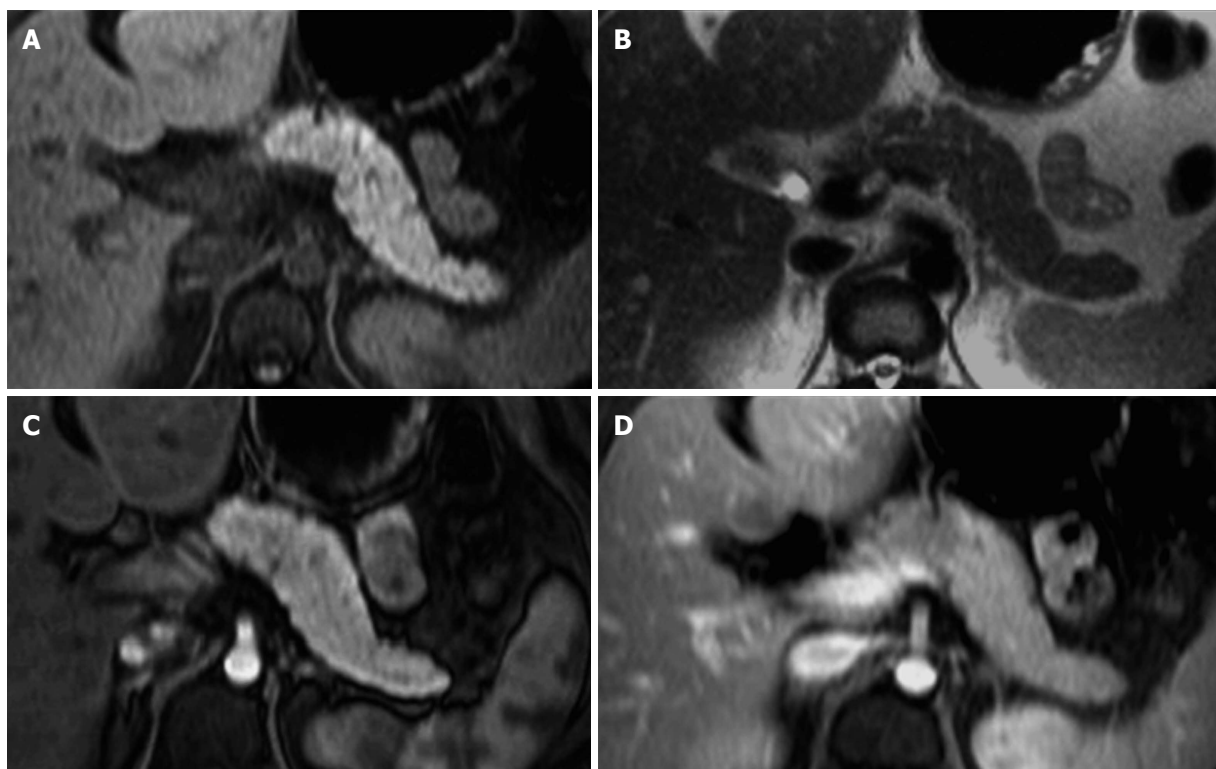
Normal pancreas. Axial T2-weighted SS-ETSE (A), pre-contrast fat-suppressed T1-weighted (B) GRE and post-gadolinium fat-suppressed T1-weighted gradient echo images acquired in the arterial (C) and venous (D) phases of enhancement. The normal pancreas is high in signal intensity on T1-weighted images (B) due to the presence of aqueous protein in the pancreatic acini. A uniform capillary blush is apparent on the immediate post-gadolinium image (C). T2-weighted sequences allow the depiction of the pancreatic duct. SS-ETSE: Single-shot echo train spin echo; GRE: Gradient echo.
